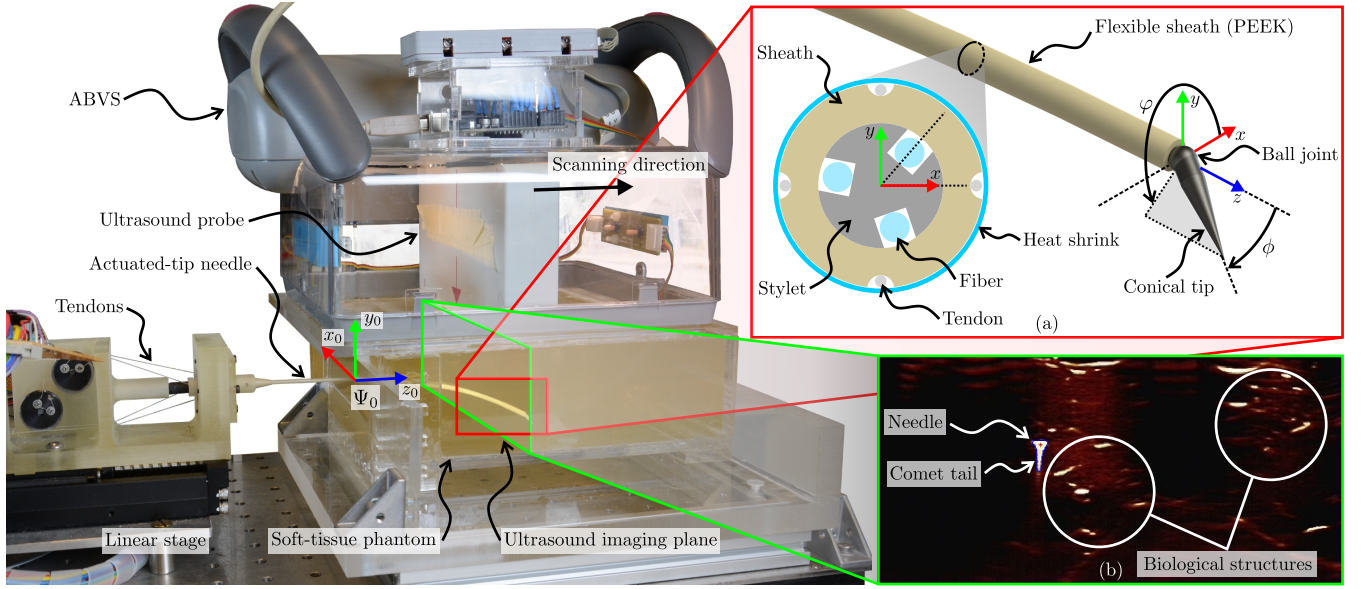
The experimental setup consists of a flexible needle which is mounted on a linear stage to enable insertion into biological tissue (chicken breast). (a) The flexible needle has an actuated-tip, consisting of a conical tip mounted on a ball joint. Actuated-tip orientation is defined by the steering direction angle (φ), and the steering angle (ϕ). The tip is actuated by four tendons, which run through the outer sheath and are held in place by heat shrink. The stylet is made of a Nitinol wire (diameter 1 mm), in which three optical fibers are integrated in grooves. (b) An Automated Breast Volume Scanner (ABVS) is used to track the needle tip during insertion using ultrasound images.
